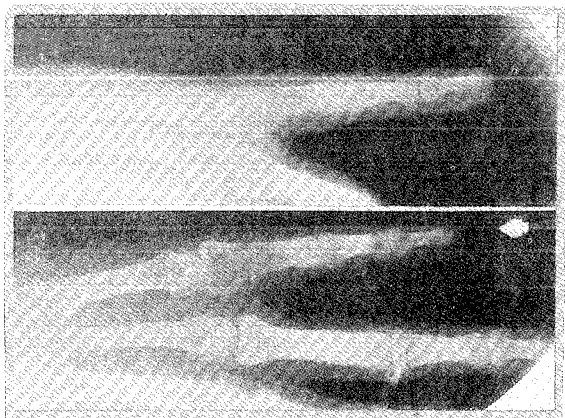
Pre-operative x-rays of right little finger showing a giant cell tumor of the proximal phalanx.
